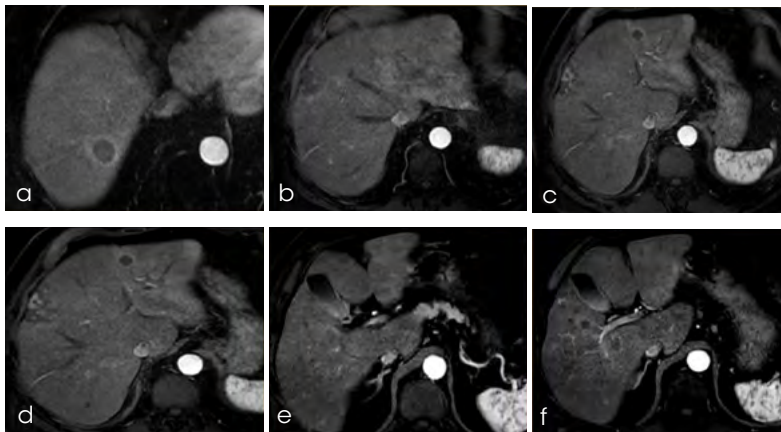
3-month post DSM-TACE CT scans show an almost complete response with necrosis of almost all hepatic lesions, without complications (a-f)
